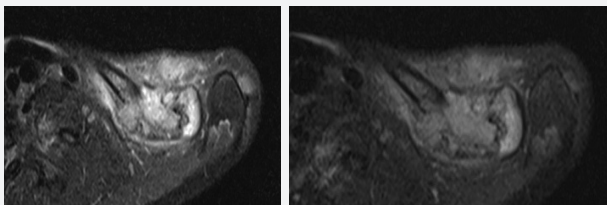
Cortical destruction in the bone and the effect of peritumoral oedema on the surrounding soft tissue seen on axial slice MRI
